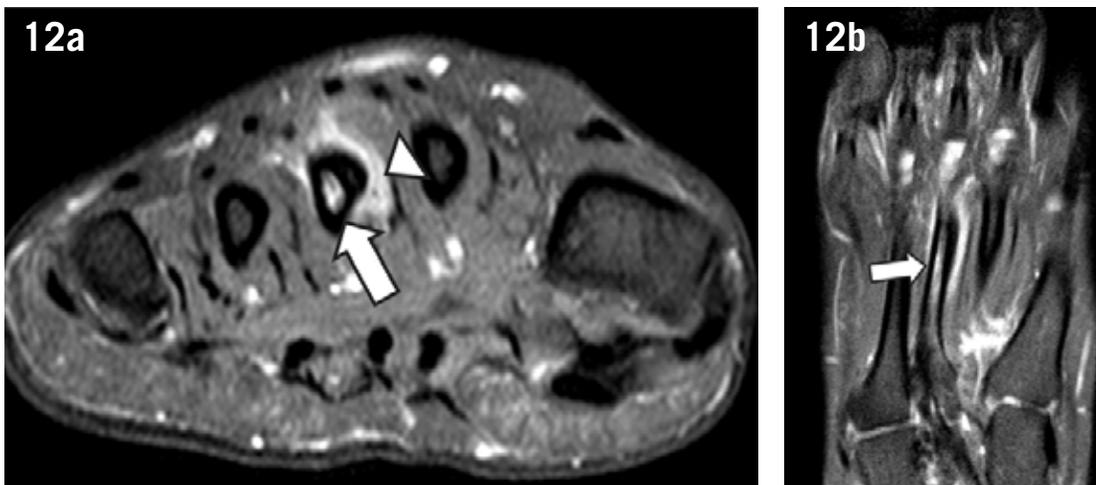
Magnetic resonance imaging of a stress reaction in the third metatarsal bone. Short (a) and long (b) axis T2 weighted images with fat saturation depicting bone marrow edema in the diaphysis of the third metatarsal bone (arrows) as well as periosteal edema (arrowhead) consistent with a stress reaction. No fracture line is seen.
